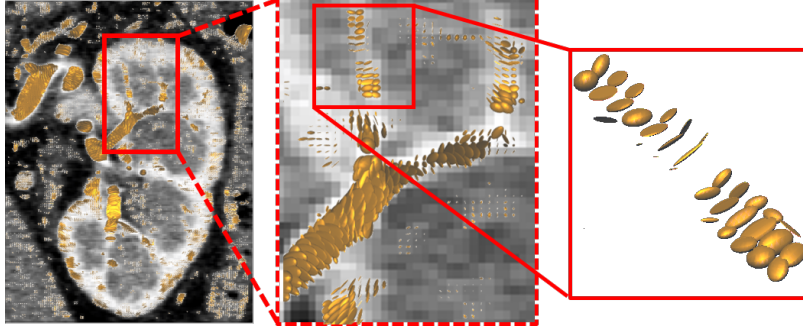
Constructed tensor field of one CT slice. Only tensors with $\mathcal{V}_{max} > 0$ are shown.
